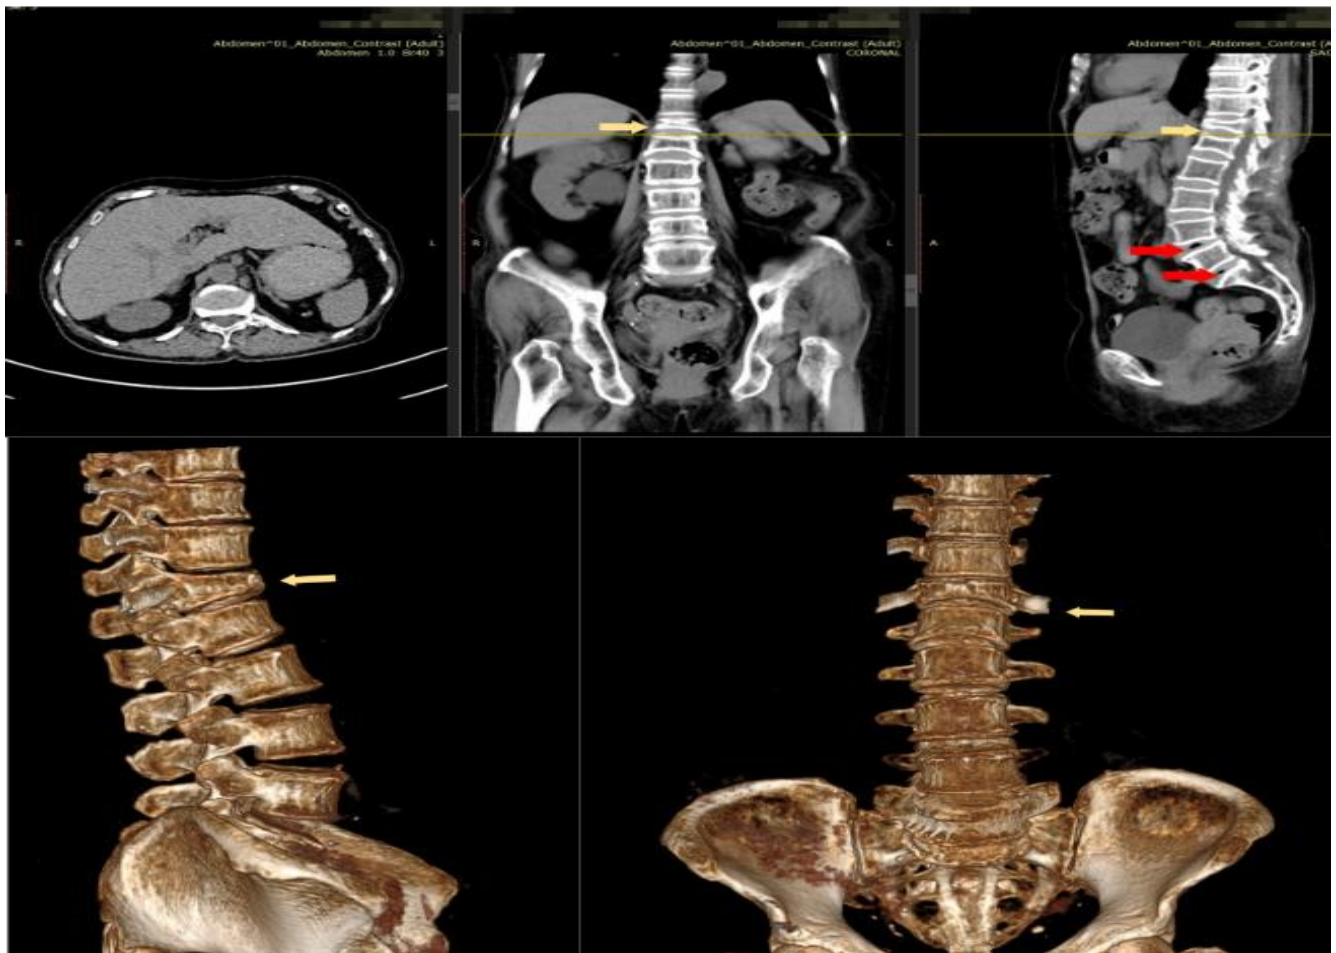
3D sagittal, coronal, and axial CT scan views of the thoracolumbar spine; osteophyte lesions found on the thoracolumbar vertebral bodies (yellow arrow); vacuum phenomenon at the L4-L5, and L5-S1 intervertebral disc spaces (red arrow); Sclerotic changes at the inferior endplate of the L2 vertebral body; and axial compression at the T12 and L1 vertebral bodies.
